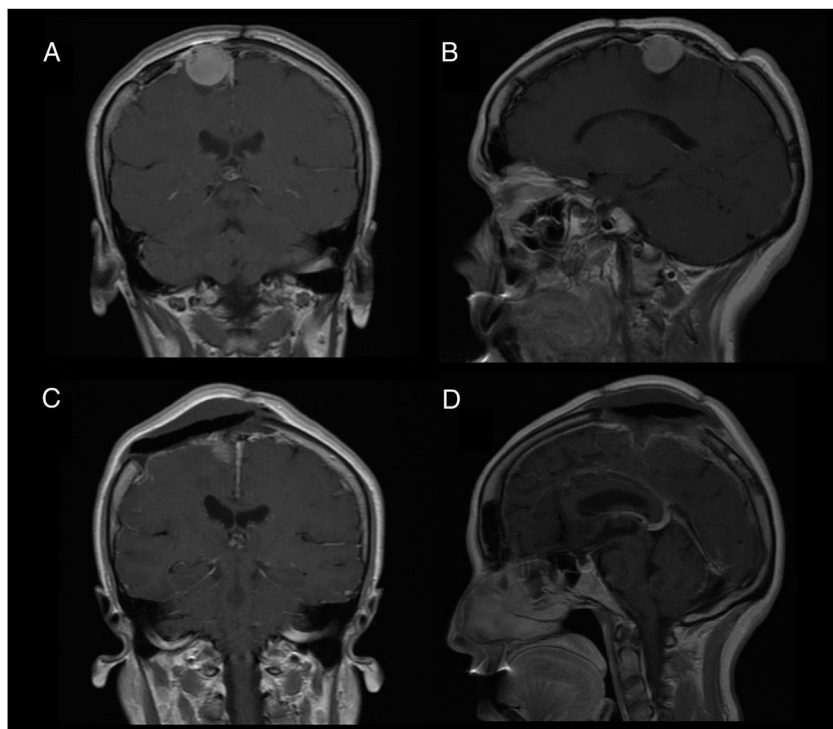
Patient 2: T1-weighted MRI scan with contrast administration. A and B) Preoperative images of recurrent tumour (patient recently admitted to hospital). C and D) Postoperative follow-up images.
